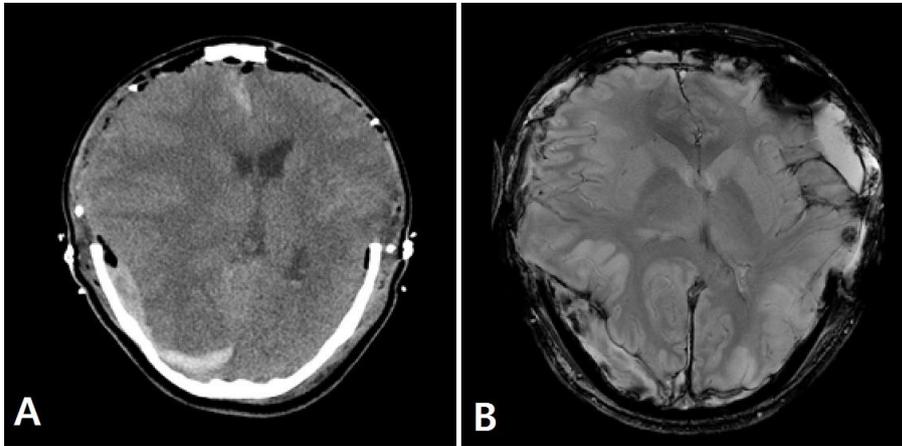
Brain imaging after bilateral craniectomy revealed severe traumatic brain injury. Brain CT showed traumatic subdural hemorrhage on both fronto-temporo-parietal convexity and severe brain edema (A). A GRE image on brain MRI showed diffuse axonal injury (B).
